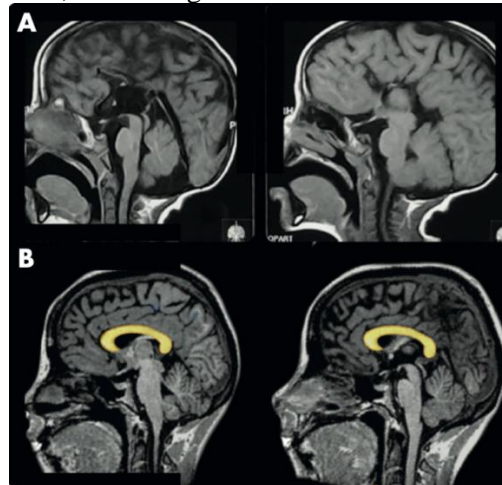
T1-weighted MRI
